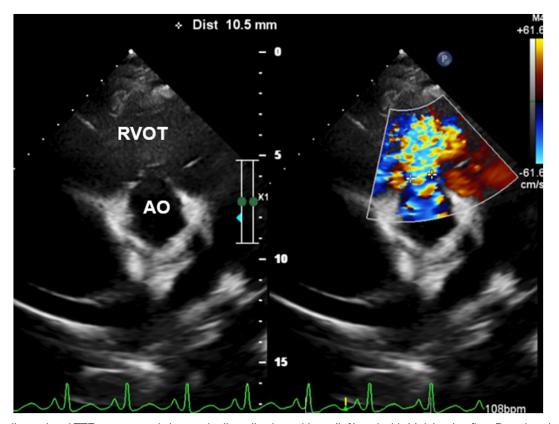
Two-dimensional TTE, parasternal short-axis diastolic view without (left) and with (right) color-flow Doppler, demonstrates a ruptured SOVA (10.5 mm) with a left-to-right shunt from the aorta toward the right ventricle.
